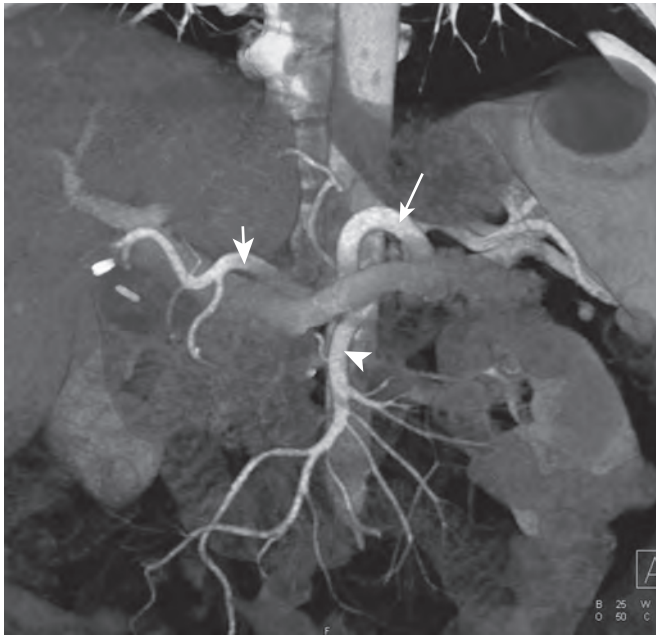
Coronal volume-rendered CT angiogram. This demonstrates the normal anatomy of the celiac axis (splenic artery, long arrow; common hepatic artery, short arrow) and superior mesenteric artery (arrowhead). The coronal projection allows easy identification of the branches arising from the SMA.
